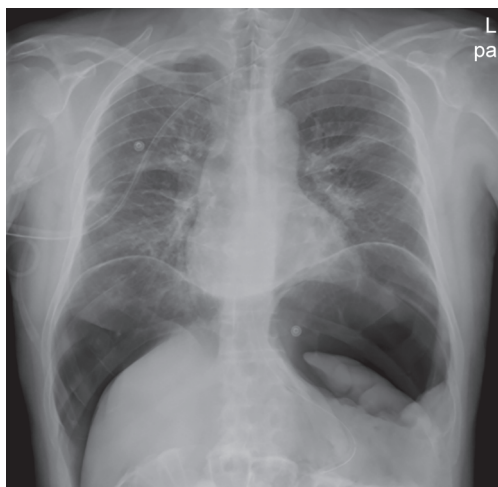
Abdominal X-ray showed a massive pneumoperitoneum
